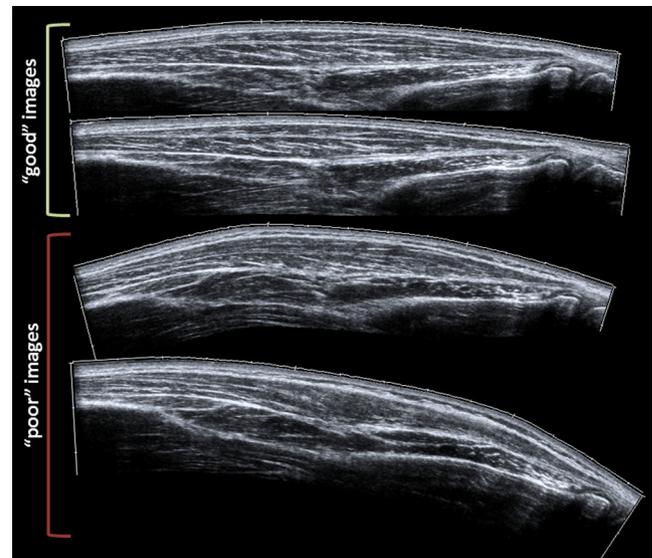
Qualitatively “good” and “poor” EFOV-US images. EFOV-US images captured from a single subject and qualitatively assessed by an experienced sonographer at the time of data collection as “good” or “poor” (only “good” images were analyzed). The sonographer assesses the presence and clarity of key anatomical features of the image, shown here are differentiations based on echogenicity, the tissue's ability to reflect ultrasound waves (Ihnatsenka and Boezaart, 2010). The “good” ultrasound images (top two images) allow identification of the ECU as the hypoechoic (dark) structure, outlined superficially and deep by muscle fascia, visible as hyperechoic (bright) lines, with connective tissue between muscle fascicles also visible as hyperechoic (bright) striations. Also visible is a hyperechoic central inner tendon that starts distally and spans approximately 75% of the captured muscle belly. “Poor” ultrasound images (bottom two images) lack one or more of these key anatomical features at any point along the length of the image. Here, the “poor” images lack both fascicles and the central tendon across the entirety of the muscle. Deviation from the imaging plane of the object yields blatantly “poor” images, which would not be analyzed. Notably, the EFOV-US algorithm is robust enough that small off plane motions, that occur inadvertently due to manual scanning, do not affect the method's accuracy (Weng et al., 1997).
